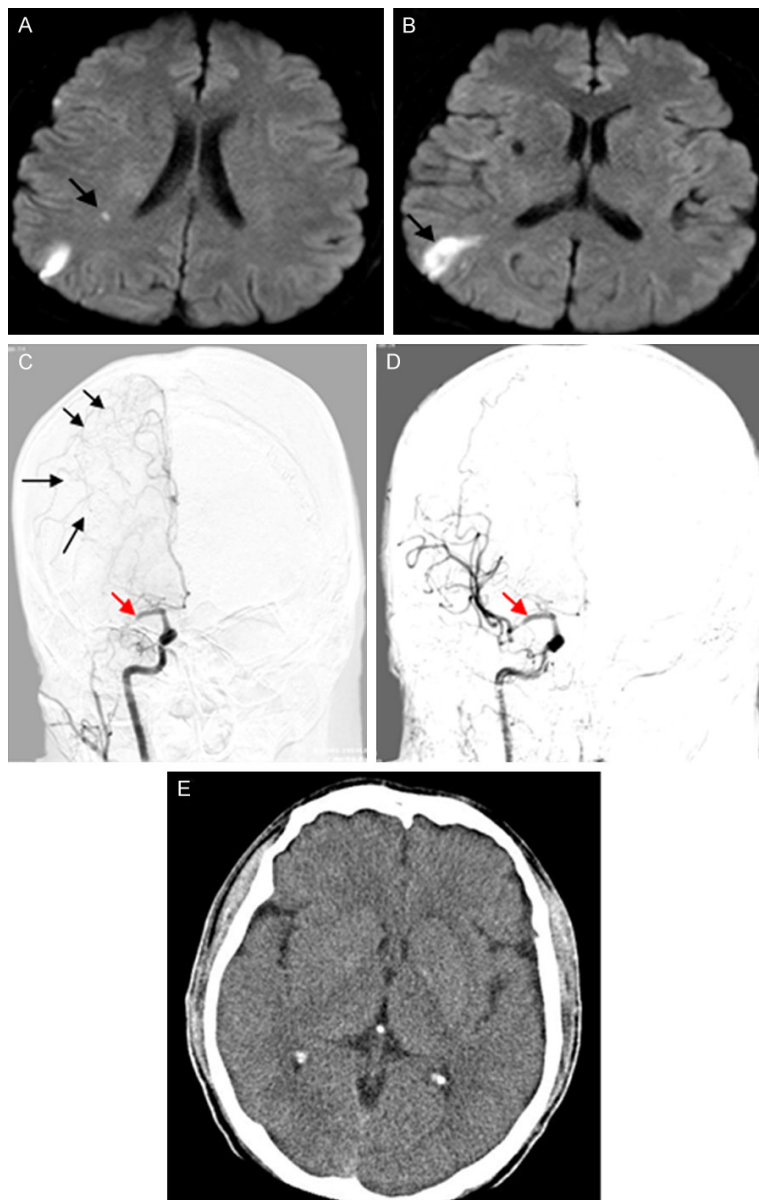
Radiographic and angiographic images of Case 2. A. DWI showed a fresh infarction in the right basal ganglia area (black arrow). B. DWI showed fresh infarctions in the right corona radiata (black arrow), MR brain DWI image before thrombolysis. C. Cerebral angiographic images showed the occluded right MCA (red arrow) and compensatory leptomeningeal arteries from anterior cerebral artery (black arrows). D. Postoperative angiographic images showed the recanalized right MCA (red arrow). E. Postoperative CT showed no hemorrhagic transformation of brain.
